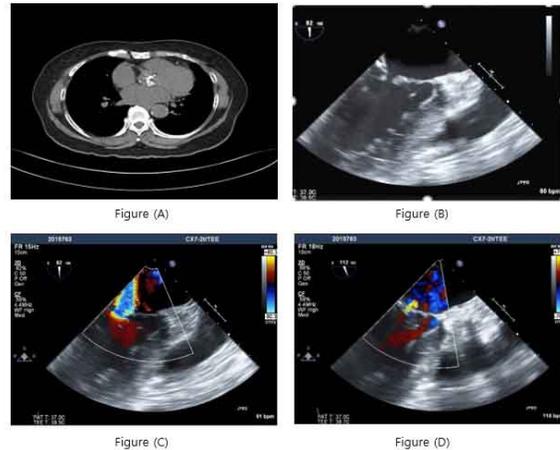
(A) Pre-procedural computed tomography showed significant aortic leaflet calcification. (B) Mid-esophageal 130° Transesophageal echocardiography view showed the absence of coaptation of both mitral valve leaflets, resulting in (C) severe mitral regurgitation. (D) At the end of procedure, valve anatomy returned to baseline, with normal leaflet coaptation and only mild MR.
